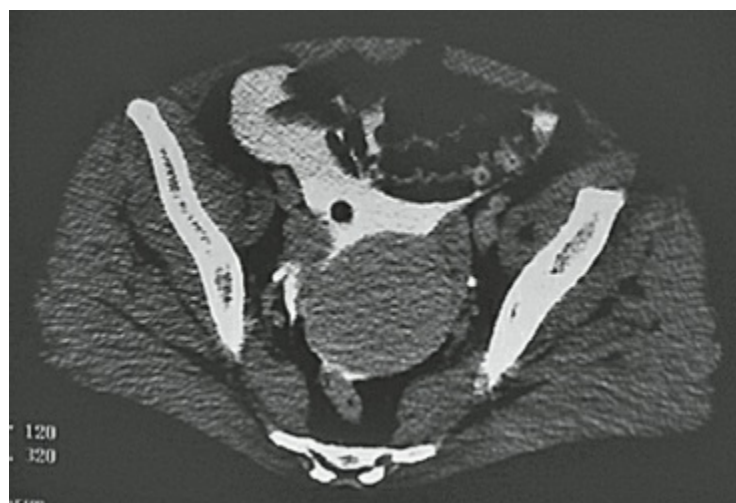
CT cystography for intraperitoneal bladder injury.
